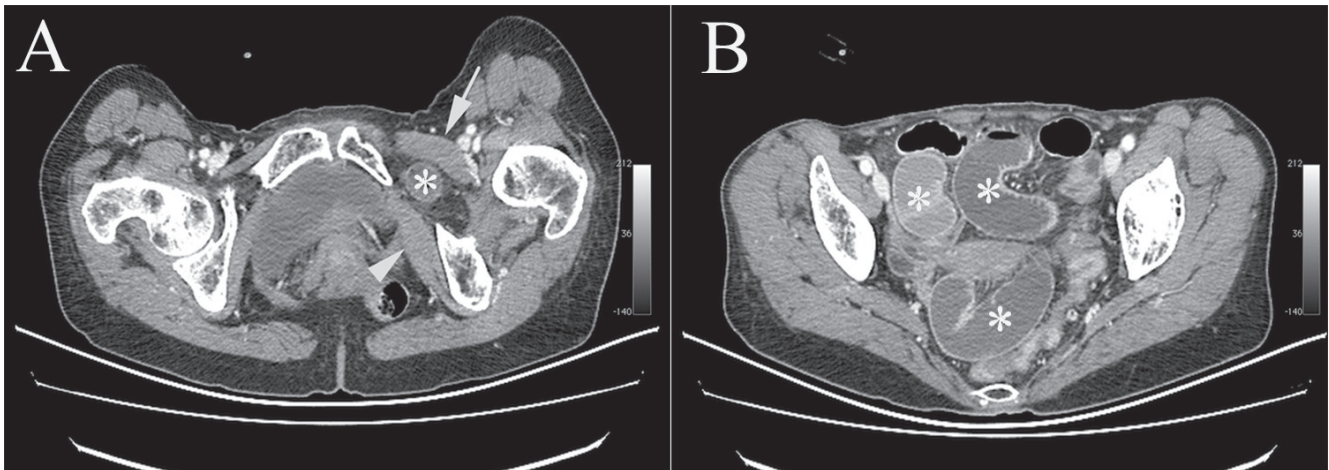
CT showed a bowel loop (asterisk) between the left obturator externus (arrowhead) and pectineus muscles (arrow)(A), Dilated small bowel loops filled with fluid (B), consistent with a diagnosis of small-bowel obstruction secondary to an obturator hernia.
